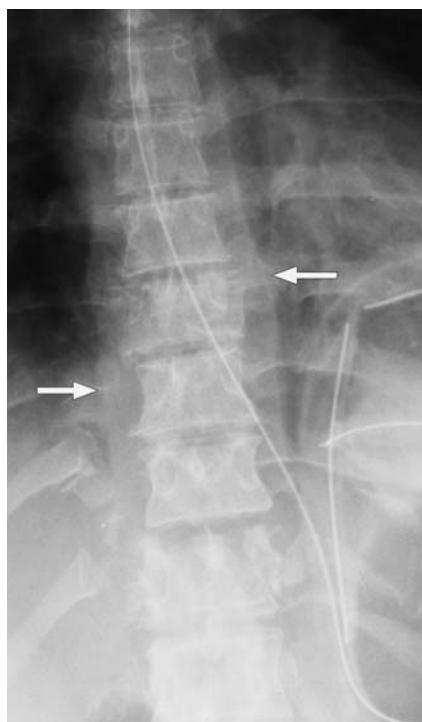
AP radiograph showing paraspinal soft tissue mass indicating hematoma (arrows) associated with fractures of T9 and T12, rib fractures, and costovertebral dislocation
